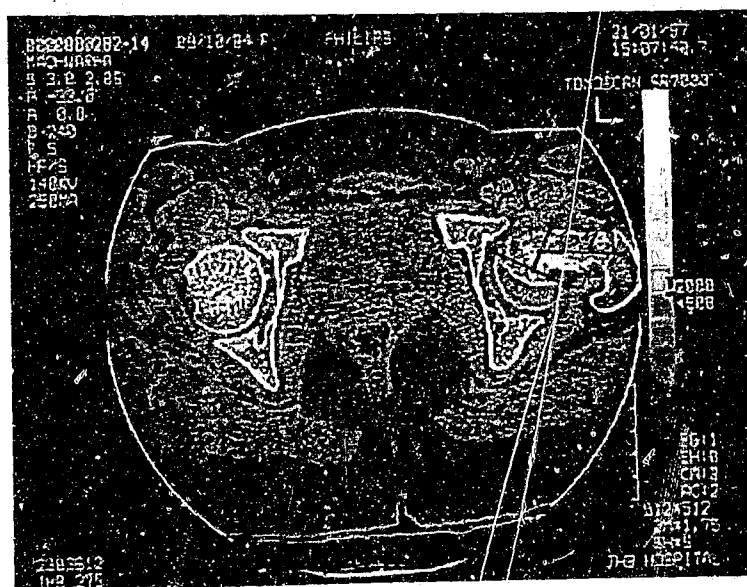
CT scan of the pelvis through both hips. The left hip shows a SCFE and Cohen's angle of 64° .
